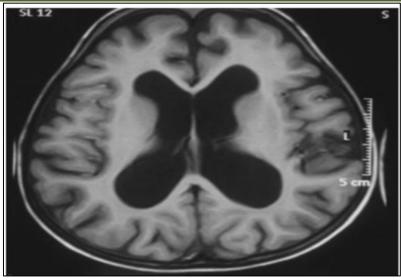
Brain MRI showing typical passive dilatation of the ventricles, with cerebral atrophy in a child with CINCA syndrome [14]
